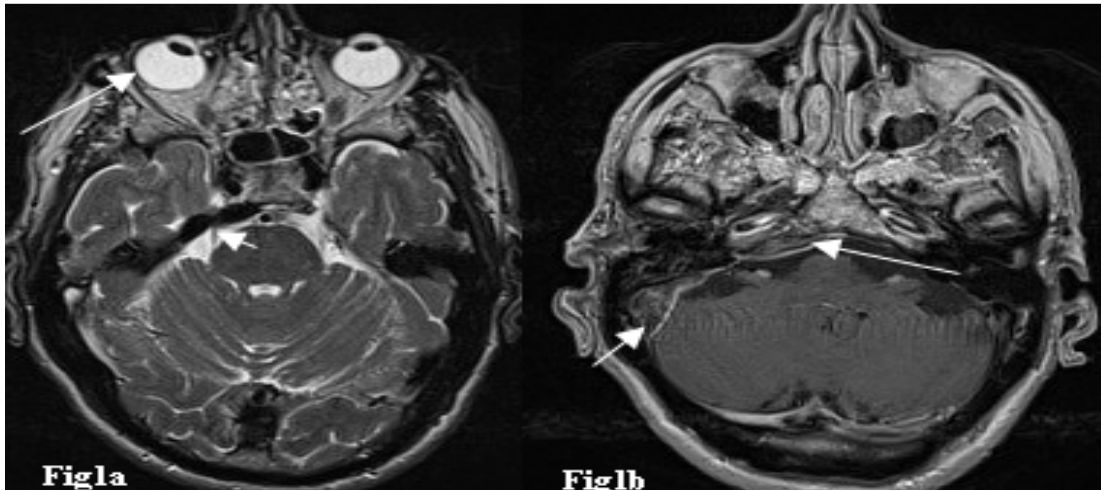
Axial T2-weighted image of the brain shows a medially deviated right eye globe consistent with right 6th nerve palsy (long white arrow). The right trigeminal nerve is being impinged upon by a hypointense abnormality along the right petrous ridge (short white arrow).
